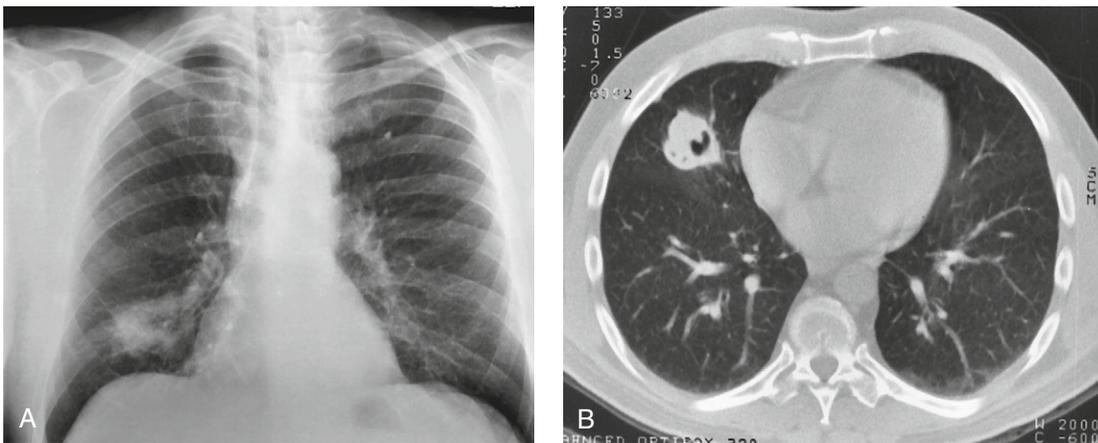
Cryptococcosis in an asymptomatic 62-year-old man. (A) PA chest radiograph shows a large, irregular right middle lobe mass. (B) Contrast-enhanced chest CT image (lung window) reveals a cavitary mass with thick irregular walls and lobulated borders. Bronchoscopy and needle biopsy demonstrated *Cryptococcus neoformans* organisms. On oral fluconazole treatment almost complete resolution of the mass occurred.
